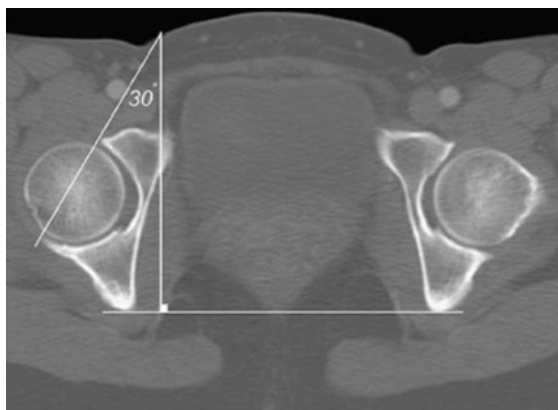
Equatorial edge angle (EEA) measured at the level of the femoral head center using axial CT scan cuts.
